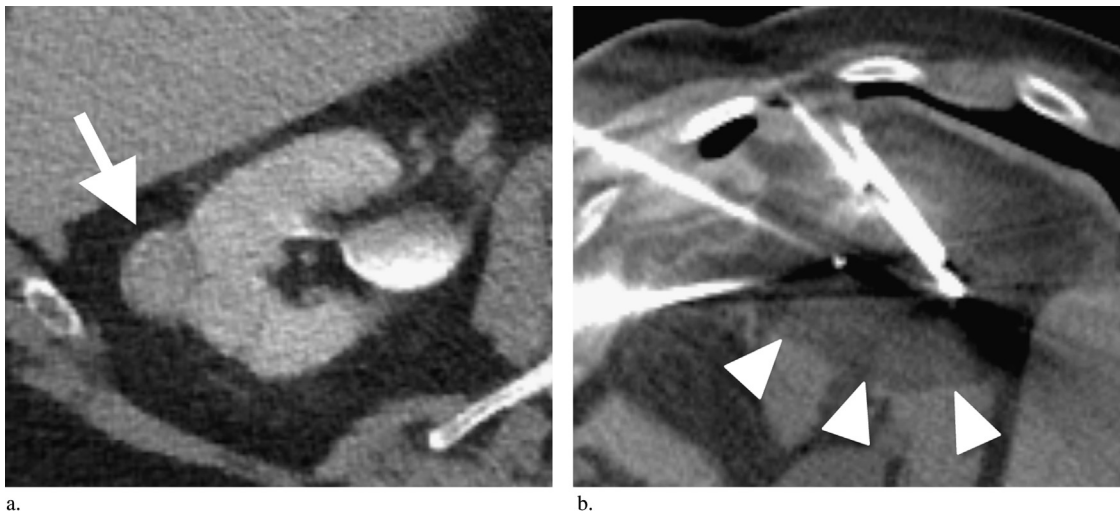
(a) Preprocedure contrast-enhanced axial CT imaging. The arrow points to a solid, enhancing, largely exophytic 2-cm right interpole renal mass. No perirenal infiltration or soft-tissue nodules were evident before ablation. (b) Intraprocedural noncontrast axial CT-guided percutaneous cryotherapy was performed. Arrowheads demarcate ice ball margins during the second freeze phase.
